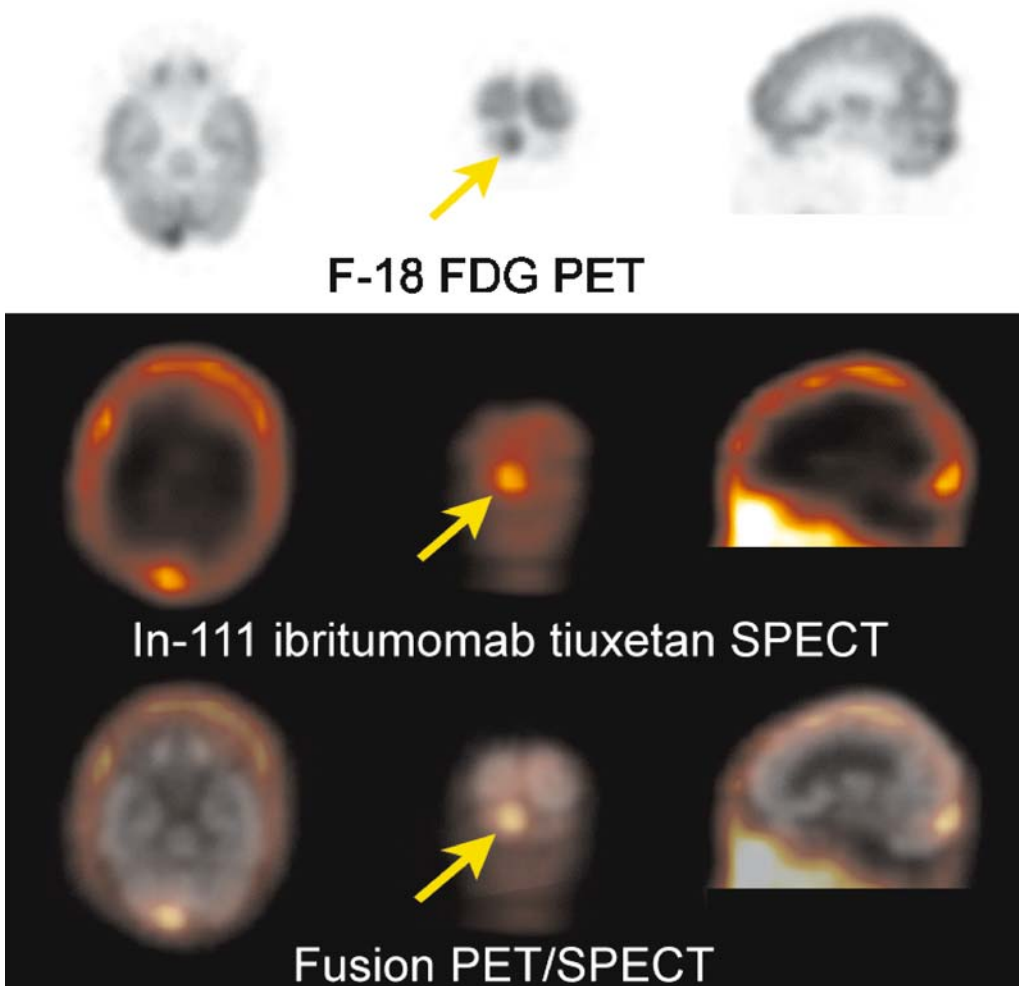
Penetration of ^{111}In ibritumomab tiuxetan through the blood–brain (-tumor) barrier in PCNSL. PET with increased uptake of ^{18}F FDG (*upper panel*), corresponding SPECT slices (*middle panel*) with increased uptake of ^{111}In ibritumomab tiuxetan, and image fusion of both modalities (*lower panel*)
